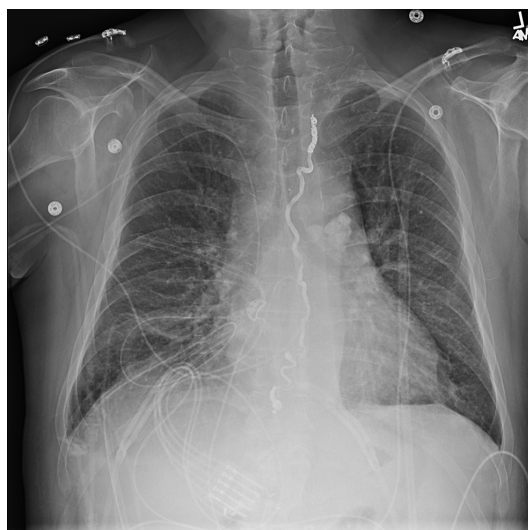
PA chest X-ray showing the anatomy of the thoracic duct. The thoracic duct is filled by a radio-opaque material that the interventional radiologist used to embolise the thoracic duct.
